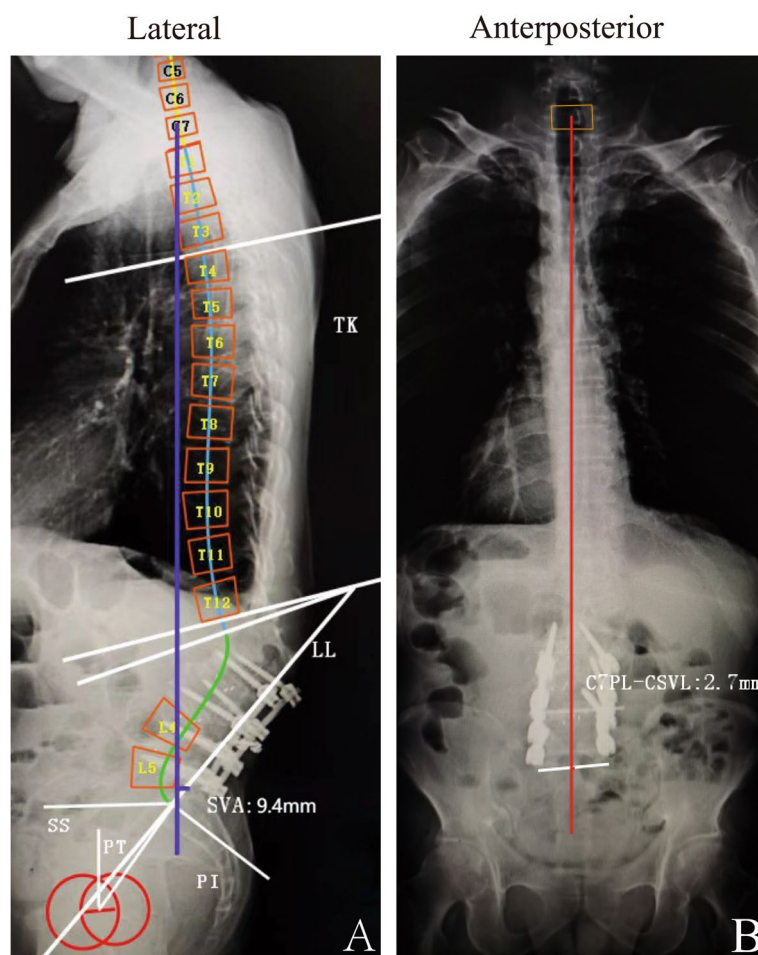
At the 24-month follow-up, the full-length anteroposterior and lateral radiographs (A and B) revealed that the sagittal vertical axis (SVA) was 9.4 mm, the coronal C7PL-CSVL was 2.7 mm, and the global alignment was within the normal range. Pelvic parameters: PI: 74.4°, PT31.1°, and SS43.3°; other parameters: TK 2.6°, LL 30.4°, and PJA 52.8°
